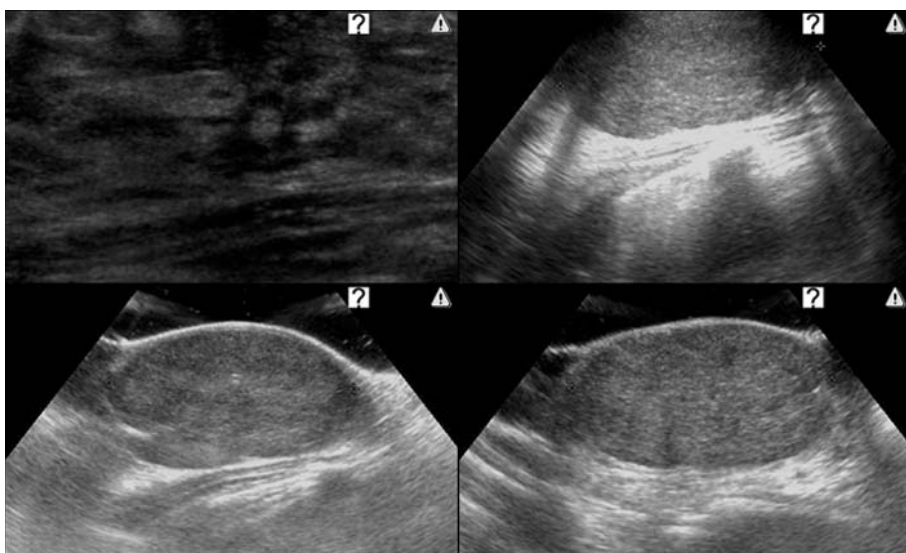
Ultrasound study shows a solid mass with low-level internal echoes
